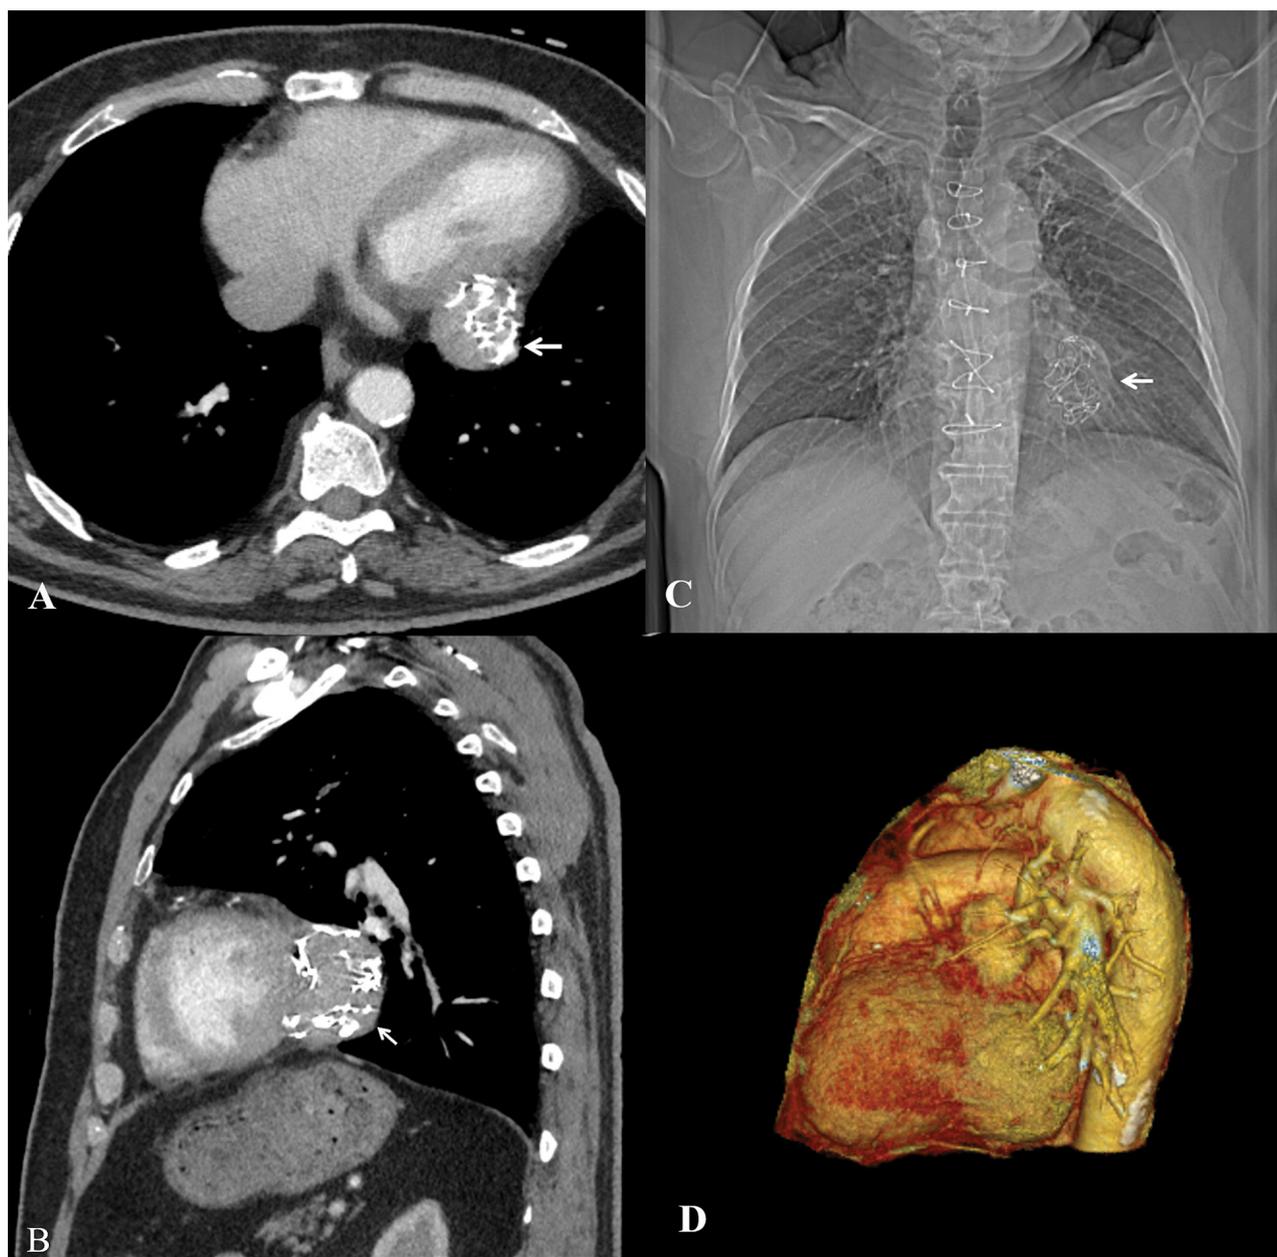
Axial (A) and sagittal (B) Plan contrast enhanced computed tomography images, scout image (C), and three-dimensional reformatted image (D) show a mass with high density linear areas adjacent to the left ventricular free wall, consistent with gossypiboma. The radiopaque marker is seen as high-density lines (arrows).
